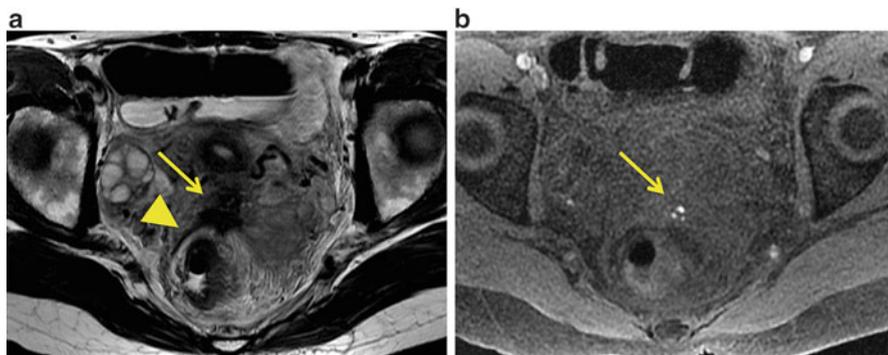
A 29-year-old woman with deep pelvic endometriosis of bilateral uterosacral ligaments. Axial T2-weighted image (a) demonstrates hypointense fibrotic plaque (*arrow*) with punctate hyperintense foci on fat-suppressed T1-weighted image (*arrow*) (b) and irregular thickening of the right uterosacral ligament (*arrowheads*)
